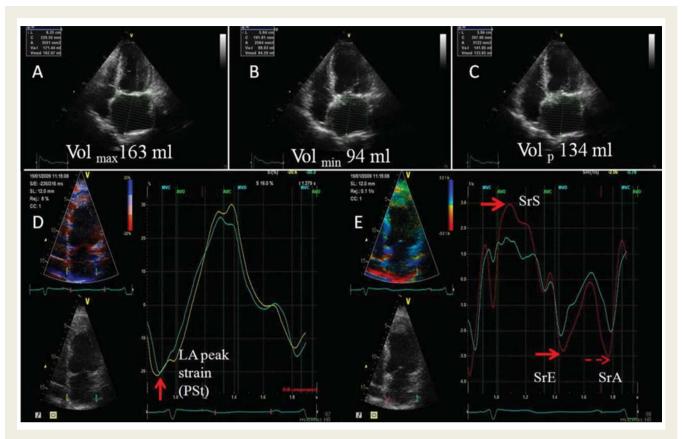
Examples of measurement of left atrial volumes and tissue Doppler strain imaging in a four-chamber view in a patient with aortic stenosis. (A) Left atrial vol_{max} , (B) left atrial vol_{min} , (C) left atrial vol_{min} , (D) left atrial peak strain curves in septal and lateral left atrial walls, and (E) left atrial strain rate curves in septal and left atrial lateral walls.
